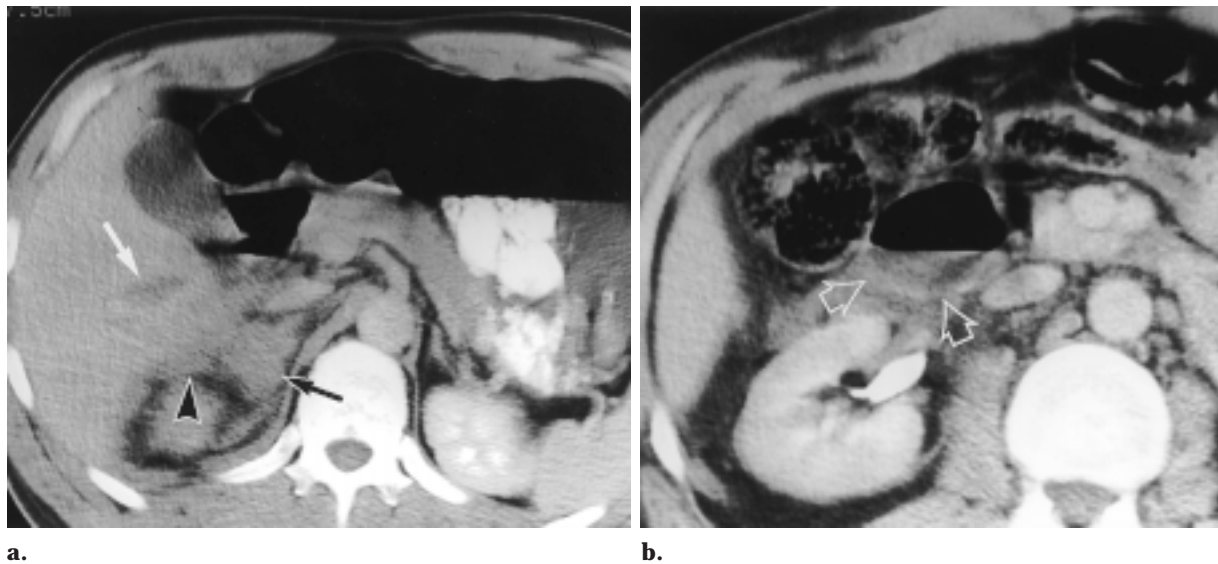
Contusion of the second portion of the duodenum, right adrenal hematoma, and intraparenchymal liver laceration in a 36-year-old man. (a) Abdominal CT scan demonstrates an intraparenchymal liver laceration (white arrow) and adrenal hematoma (black arrow), with surrounding retroperitoneal blood (arrowhead). (b) On a CT scan obtained at a lower level, periduodenal hematoma thought to be from the other injuries masks the duodenal injury (arrows), which could be suspected on the basis of its ill-defined wall and adjacent blood.
